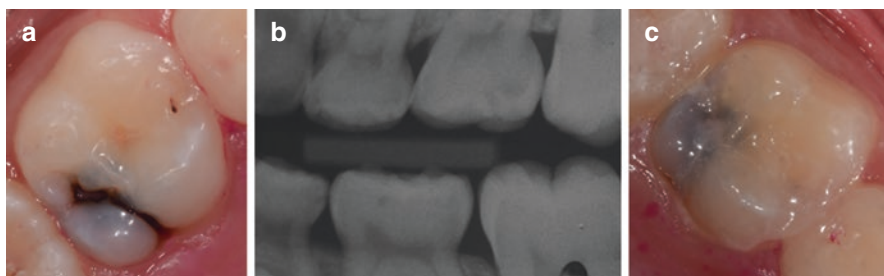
(a) Clinical aspect of a second primary molar presenting an internal caries-related discoloration. (b) The radiograph showing that the lesion is located in the outer part of the dentin. (c) Final aspect immediately after the application of a resin-modified glass-ionomer sealant
